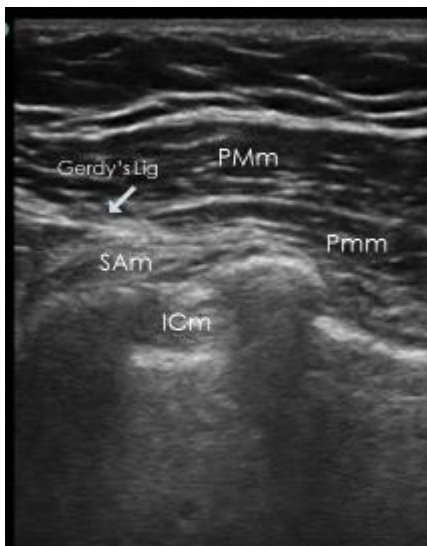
Ultrasound image for the point of 2nd injection for PECS II block.
